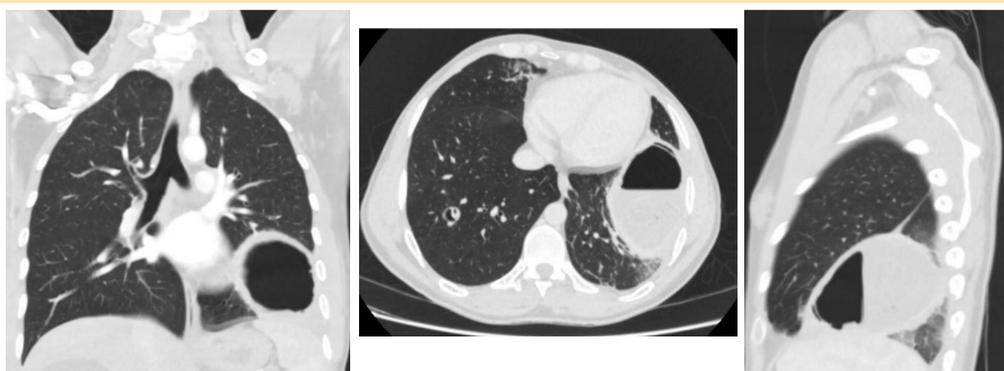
Patients images from CT Thorax showing a 7 x 7.4cm ruptured left lower lobe pulmonary hydatid cyst and another hydatid cyst in the right lower lobe measuring 2 x 1.9cm
